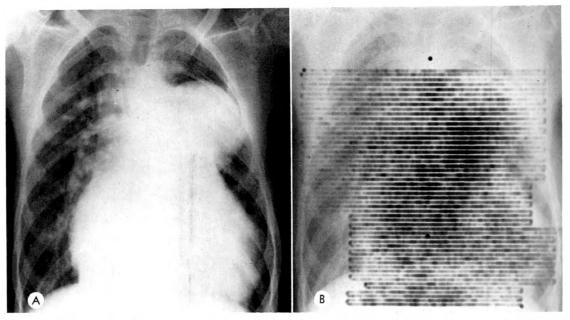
(A) Six foot, anteroposterior roentgenogram made in deep inspiration and in semi-upright position. The patient was a 20 year old man with a history of remote Potts' operation performed for palliation of tetralogy of Fallot. A large aneurysm of the pulmonary artery had developed over a period of several years. (B) Photoscan data superimposed upon matching 6 foot, anteroposterior, recumbent, midrespiration roentgenogram. Scan performed with 680 μc I<sup>131</sup> iodipamide sodium shows large blood pool approximately corresponding to location of aneurysm.
